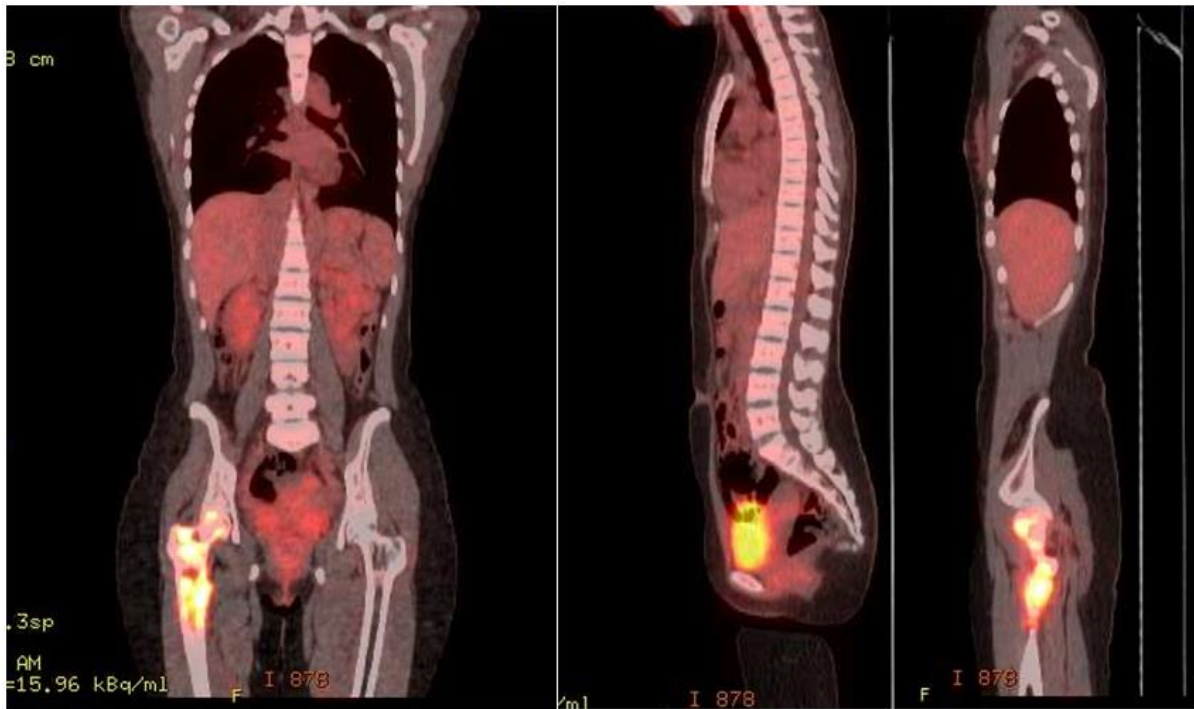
PET CT scan results showing an FDG avid sclerotic bone lesion in the right femur (head, neck, intertrochanteric regions)
